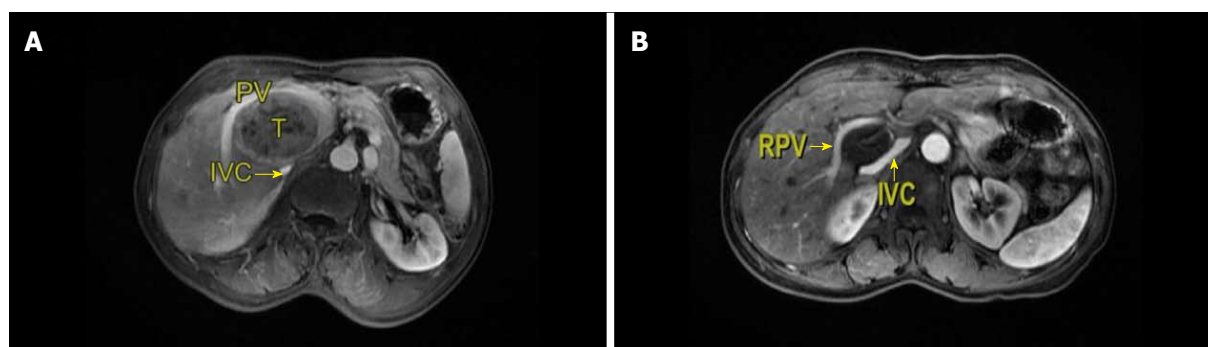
Magnetic resonance images for caudate lesions. A: T located between PV and IVC; B: Hepatic hemangioma located between RPV and IVC. IVC: Inferior vena cava; PV: Portal vein; RPV: Right portal vein; T: Tumor.
